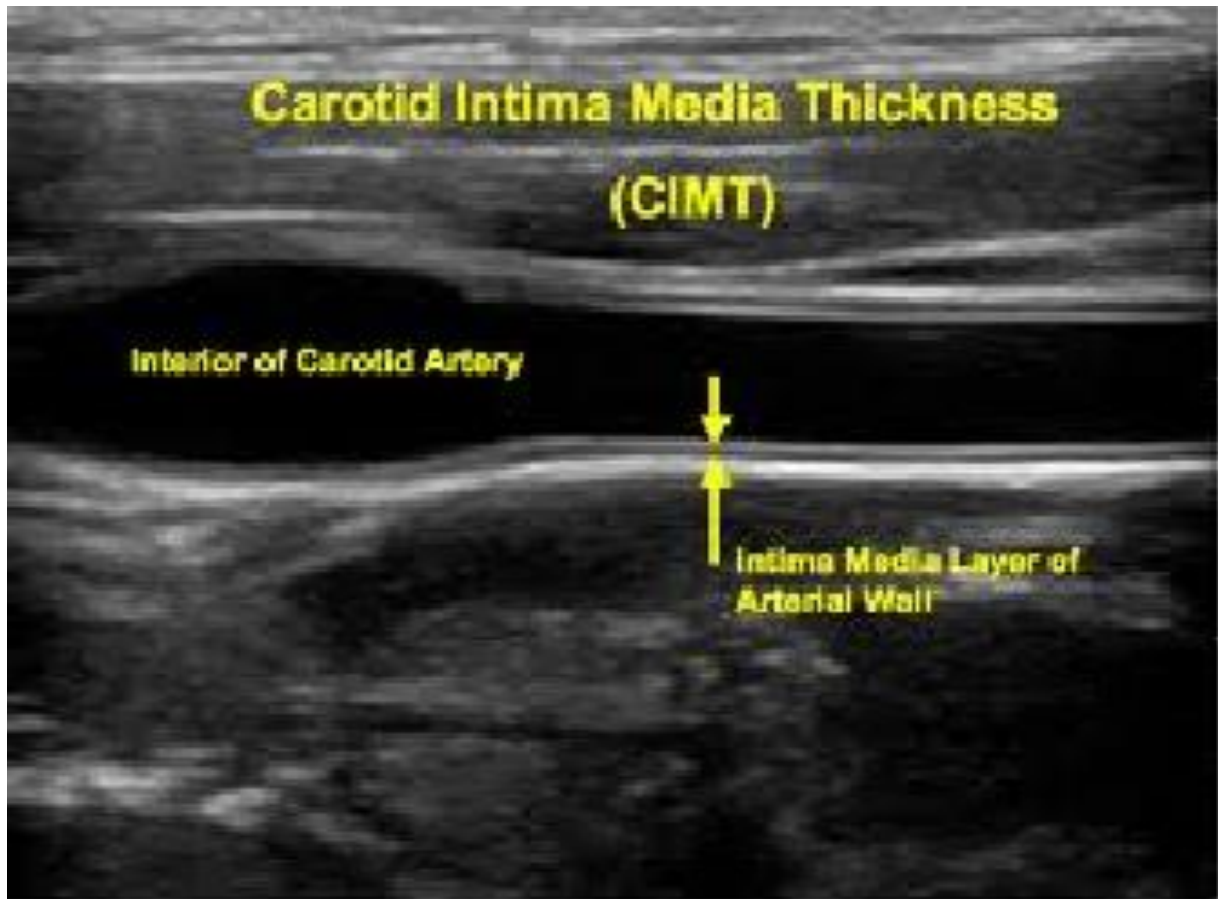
B mode Ultrasound of common carotid artery
